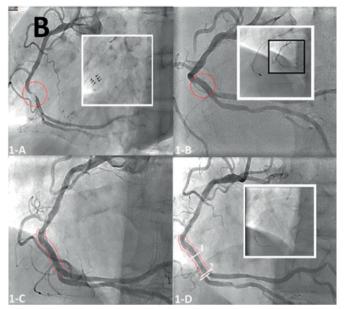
Angiogram and intravascular ultrasound (IVUS) of the right coronary artery (RCA).
